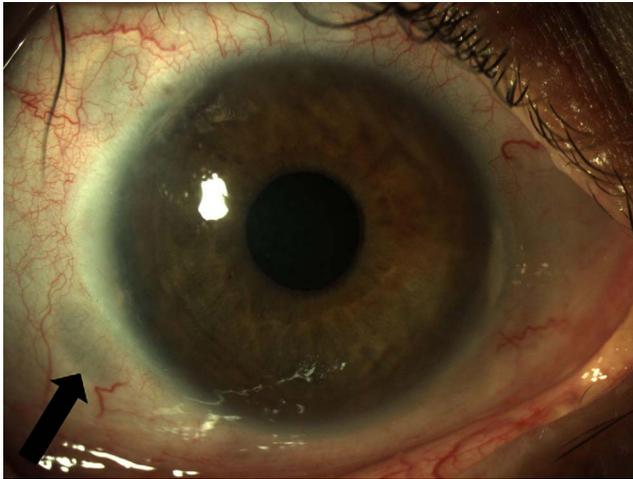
Image showing localized and nontransilluminable scleral thinning after ultrasound circular cyclo-coagulation (UC3) cyclophotocoagulation. Note that the regions appear to be well delineated, without any signs of conjunctival inflammation, induced corneal astigmatism, or scleral protrusion. *Black arrow* indicates area on 7-o'clock meridian treated.
